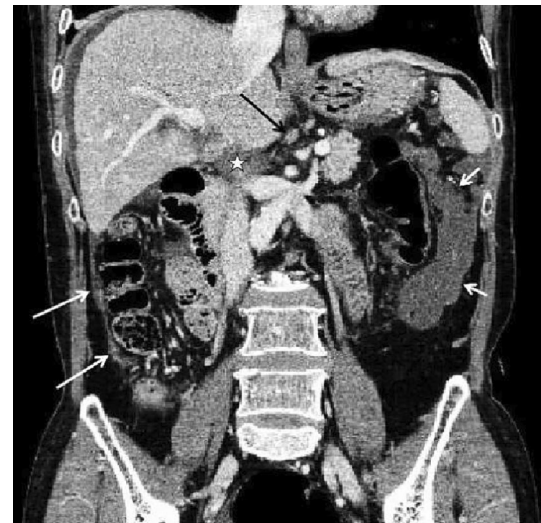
Coronal CT section through the abdomen in the venous phase in a 50-year-old woman with PC. Peritoneal nodules of the peritoneum (long white arrow), cake-like thickening of the omentum (short white arrow), enlarged LN (long black arrow) and high-density ascites (star)
